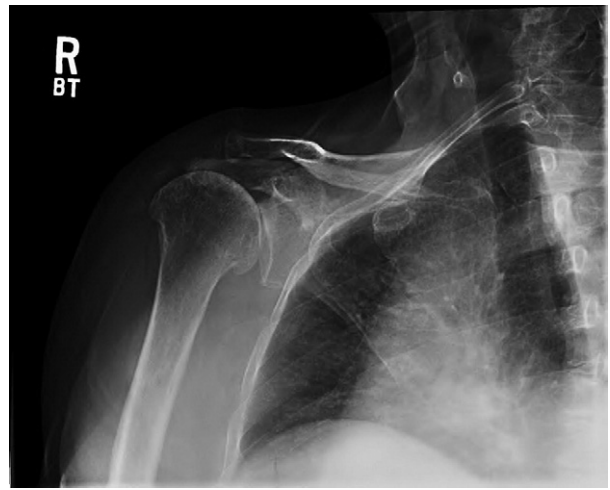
Radiograph of type 4, rotator cuff arthropathy. There is end-stage degeneration of the glenohumeral joint and articulation of the humeral head with the acromion.
